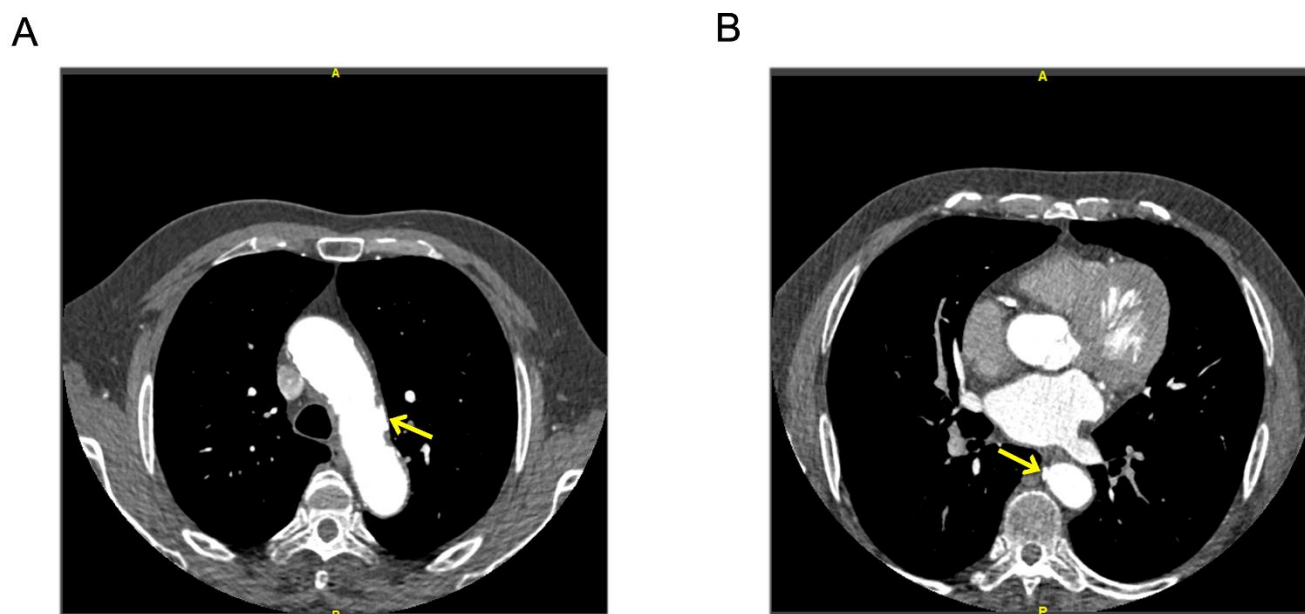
CT angiography of the aorta; A: PAU in the aortic arch; B: PAU in the descending aorta
